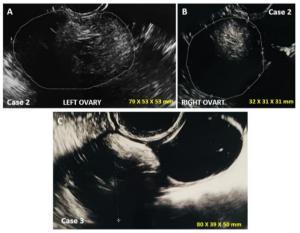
Collision of ovarian mature cystic teratoma and mucinous cystadenoma (cases 2 and 3). A, B: Case 2 transvaginal ultrasound detecting bilateral unilocular, mixed-content and non-vascularized formations (*i.e.* typical ultrasound morphology of mature cystic teratoma diagnosed in the left and right ovary); no findings suggesting a collision in the left ovary has been observed. C: Case 3 transvaginal ultrasound revealing a cystic bilocular formation, apparently originating from the left ovary, with mixed content in one of its locules and acoustic shadow.
